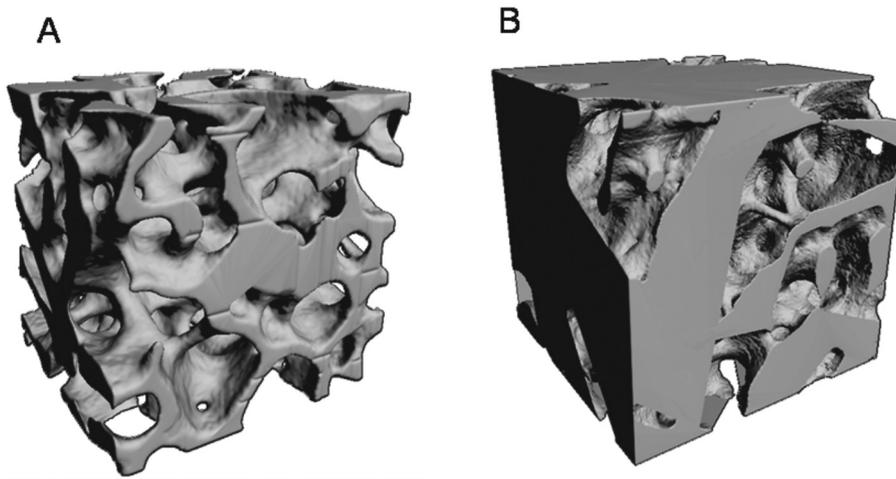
Reconstructed μ CT images of cancellous bone from a control (A) and hypoparathyroid (B) subject. Note the dense trabecular structure in hypoparathyroidism. Reproduced with permission from [20].
